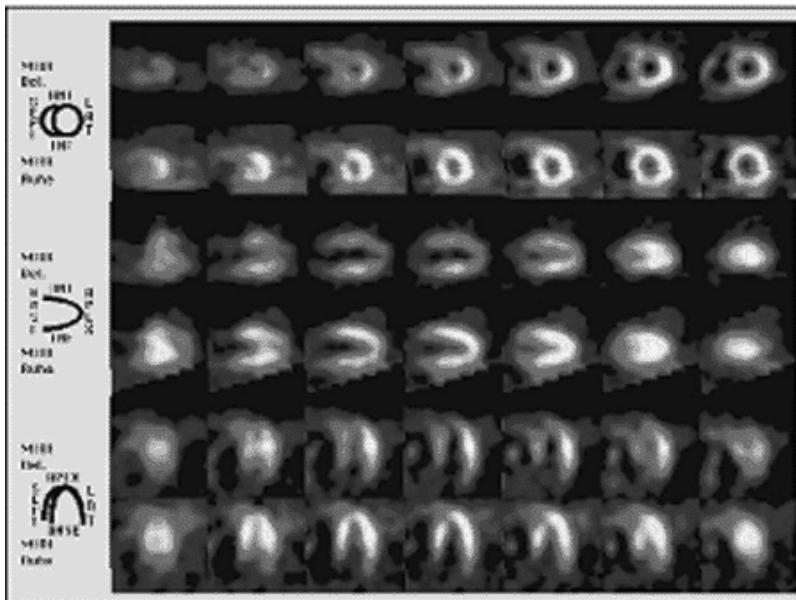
Myocardial SPECT examination in a patient with a reversible ischemia in the septum and the anterior wall (E.CAM). Row 1, 3 and 5: stress images, row 2, 4 and 6: study at rest.
